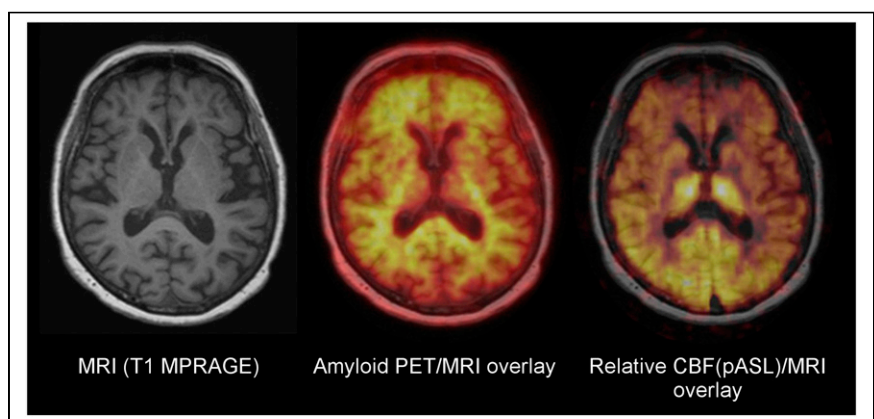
Simultaneous PET/MRI in dementia using ^{18}F -florbetaben PET and pulsed arterial spin labeling (pASL) MRI. MPRAGE = magnetization-prepared rapid gradient echo. (Reprinted from (33).)
